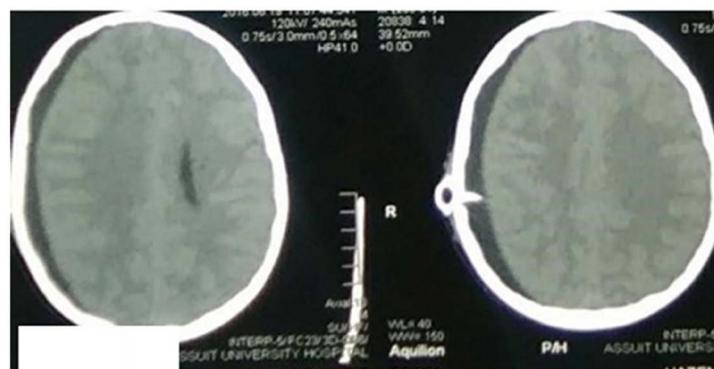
Post shunt CT brain showing marked reduction in the size of the hygroma.
